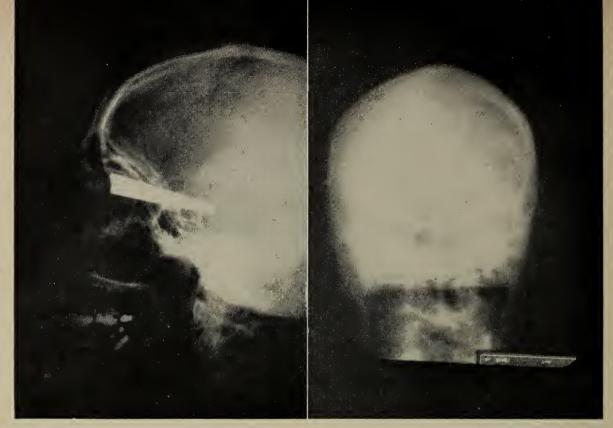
Lateral roentgenogram of the skull.
